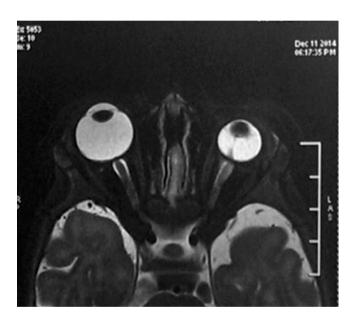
T-2 W image of MRI of a 3-month-old baby showing left eye smaller in size with hypointense stalk attached from disc to lens confirm PFV
